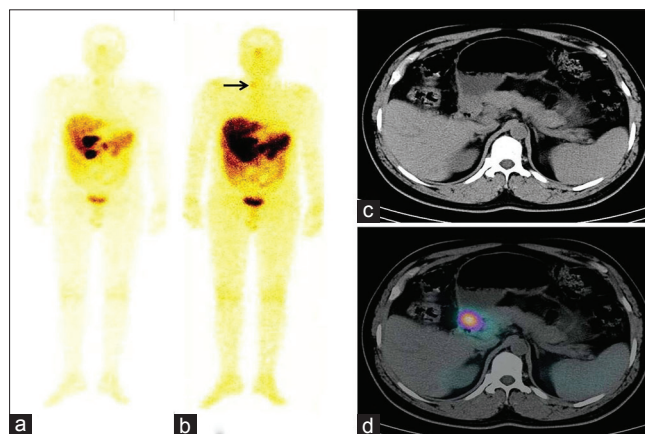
(a-d) Anterior whole-body posttherapy Lu-177 DOTATATE scans (dual intensity) at 24 h showed tracer uptake in the primary site, mesenteric lymph nodal mass liver lesions as well as in the right thyroid region (arrow). Regional transaxial computed tomography and fused single-photon emission computed tomography/computed tomography images showed tracer avid primary lesion
